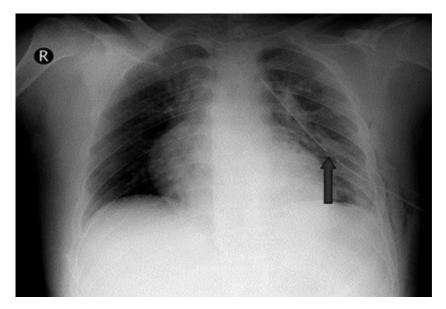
Confirm tube placement on chest radiograph (shown). Notice that the most proximal hole (arrow) is in the thoracic cavity and is seen as an interruption in the white line of the chest tube. From *Tube Thoracostomy Insertion*, by S. L. Melendez and M. A. Silverberg, 2012. Retrieved from https://reference.medscape.com/features/slideshow/tubethoracostomy. Copyright 2012 by Medscape Drugs & Diseases, WebMD LLC. Reproduced with permission.
